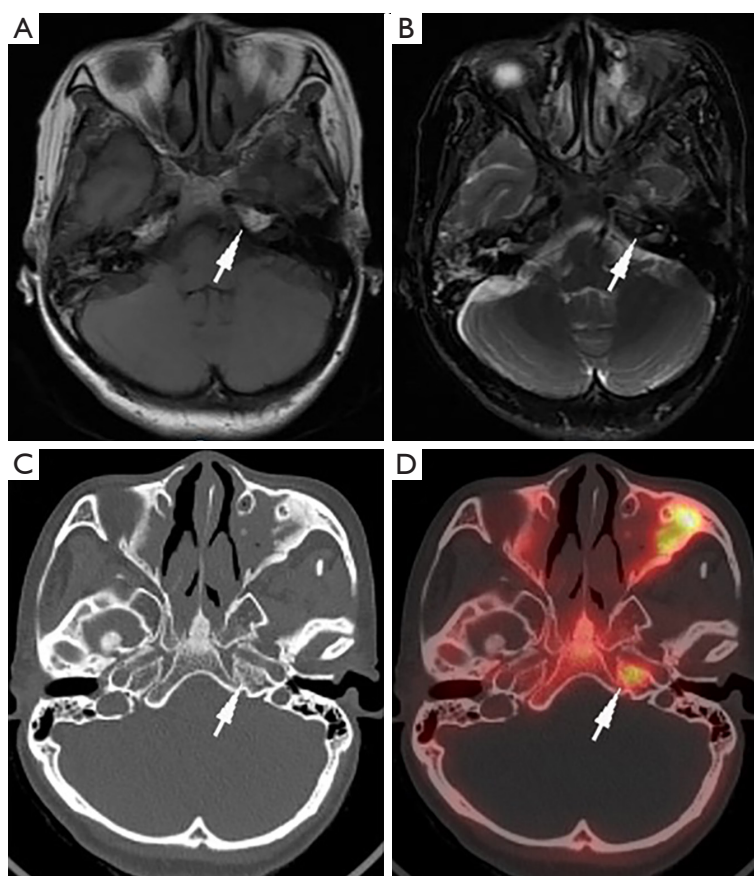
Images of a 41-year-old woman with NPC. (A) MRI-T1WI (arrow) and (B) T2WI (arrow) showed no abnormal signals in the left temporal bone. However, (C) CT revealed hyperdensity in the left temporal bone as indicated by the arrow, and (D) the ^{18}F -NaF PET/CT fusion image (arrow) subsequently demonstrated abnormal radioactive activity at the corresponding site, conclusively confirming tumor invasion in that region. This combined ^{18}F -NaF PET/CT and MRI approach effectively diagnosed SBBI. NPC, nasopharyngeal carcinoma; MRI, magnetic resonance imaging; T1WI, T1-weighted imaging; T2WI, T2-weighted imaging; CT, computed tomography; ^{18}F -NaF PET/CT, ^{18}F -sodium fluoride positron emission tomography-computed tomography; SBBI, skull-base bone invasion.
